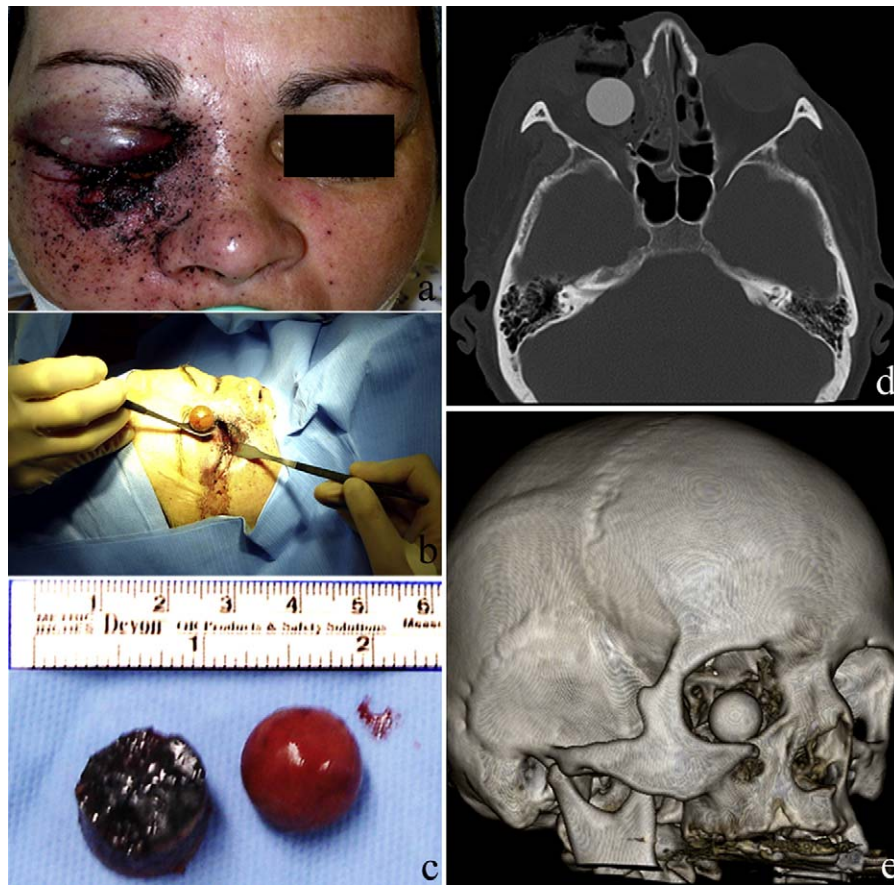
Case #1: (a) patient at admission, with extensive traumatic gunpowder tattoo and penetrating injury of the internal canthus; (b and c) the 18-mm rubber missile and the wad were extracted from the orbit; (d) the medial wall of the orbit and the right ethmoidal cells were fractured—the wad was visible anterior prior to the bullet; (e) 3D CT-scan showing the infero-medial intra-orbital localisation of the rubber bullet; right zygoma and orbital floor fractures.
